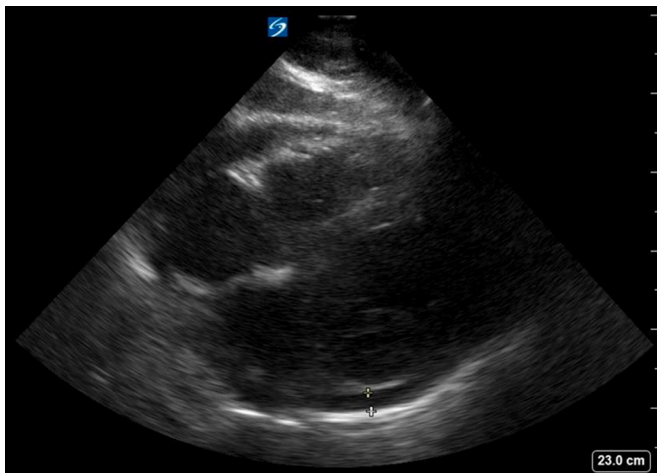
Small to moderate pericardial effusion demonstrated in parasternal long.
